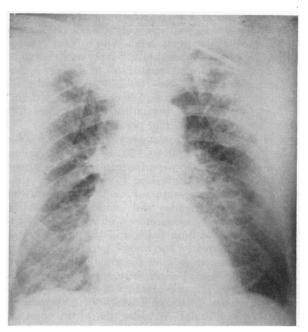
X-ray film taken after tracheotomy, interpreted as showing generalized bronchopneumonia, both lungs.
